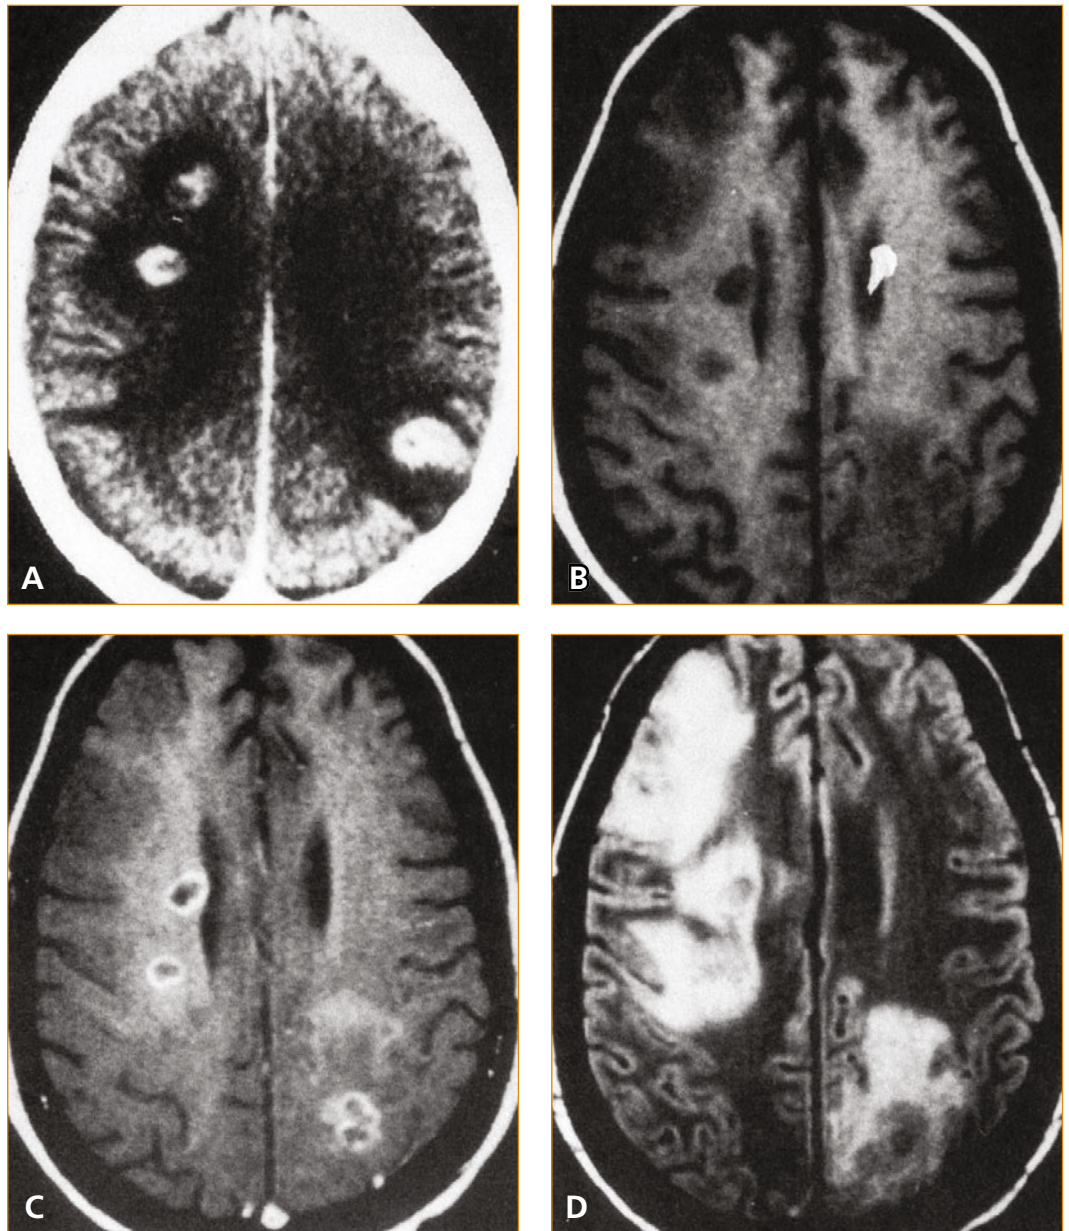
A, Axial CT scan showing multiple areas of contrast enhancement in a patient with AIDS and cerebral toxoplasmosis. B, T1-weighted images showing periventricular and gray-white junction lesions consistent with hematogenous dissemination. C, After gadolinium administration, contrast enhancement is seen on the T1-weighted image corresponding to that in B. D, Axial T2-weighted image showing edema surrounding multiple cortical and subcortical lesions. (*From Kastenbauer *et al.* [30], with permission.*)
